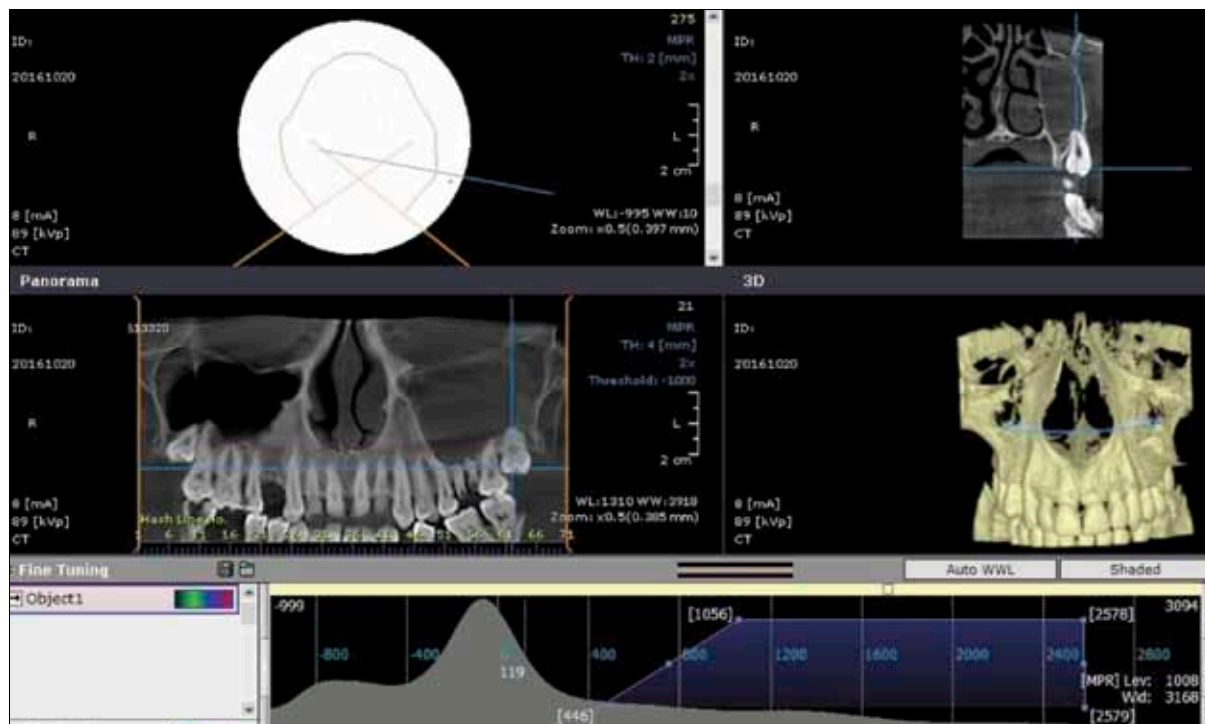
CBCT – radiolucent mass invading the entire left maxillary sinus.
